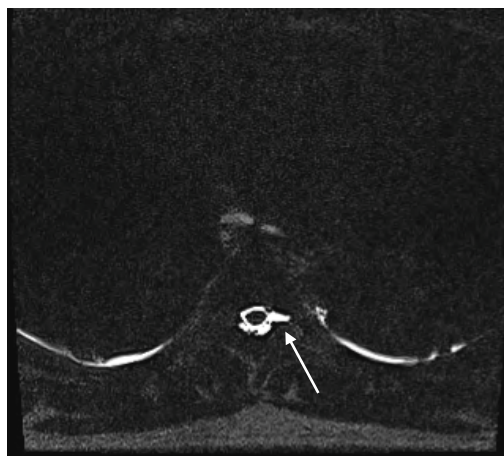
Whole spine magnetic resonance imaging myelography shows definite cerebrospinal fluid leakage in the left T5 nerve root sleeve (white arrow).
